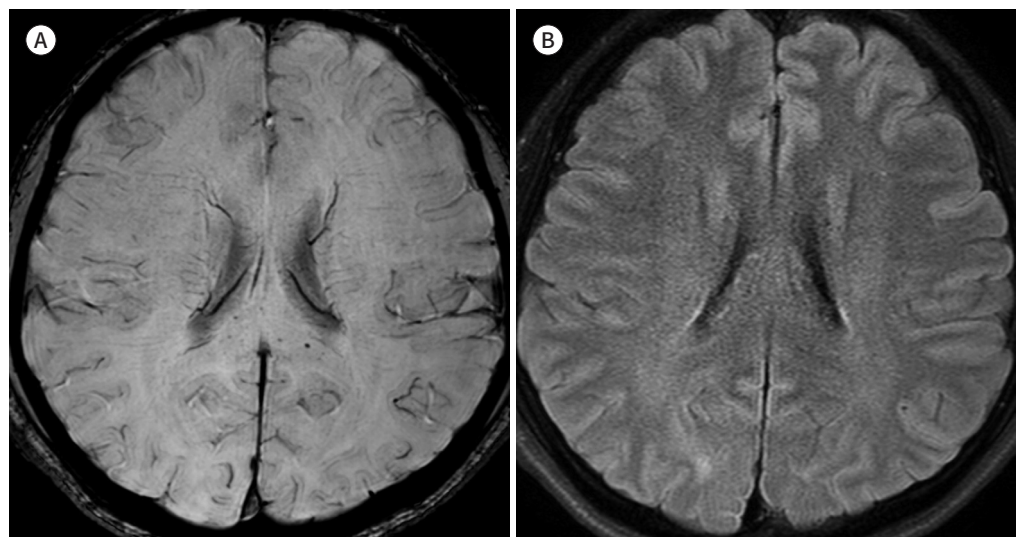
A 33-year-old man with ABI due to cardiac arrest. This patient underwent cardiopulmonary resuscitation and was successfully recovered without significant neurologic sequelae. The interval from the event of ABI to MRI acquisition was 14 days.
